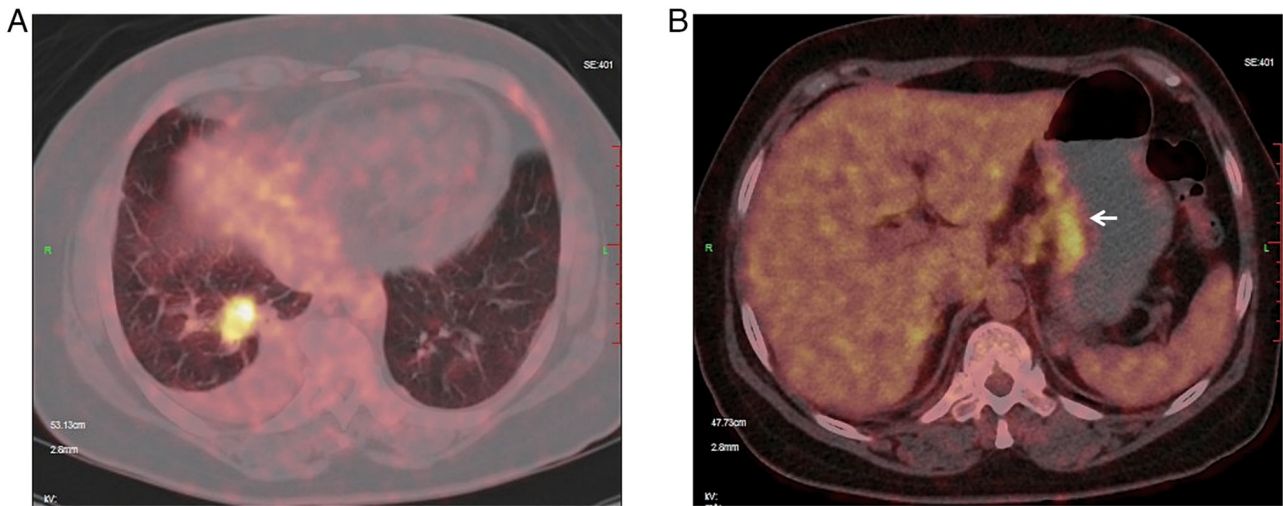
PET/CT of case 1. (A) PET/CT indicating a pulmonary nodular lesion in the right lower lobe with high FDG uptake. (B) PET/CT indicating a highly FDG-uptaking lesion in the gastric lesser curvature (arrow). PET/CT, positron emission tomography/computed tomography; FDG, fluorodeoxyglucose.
